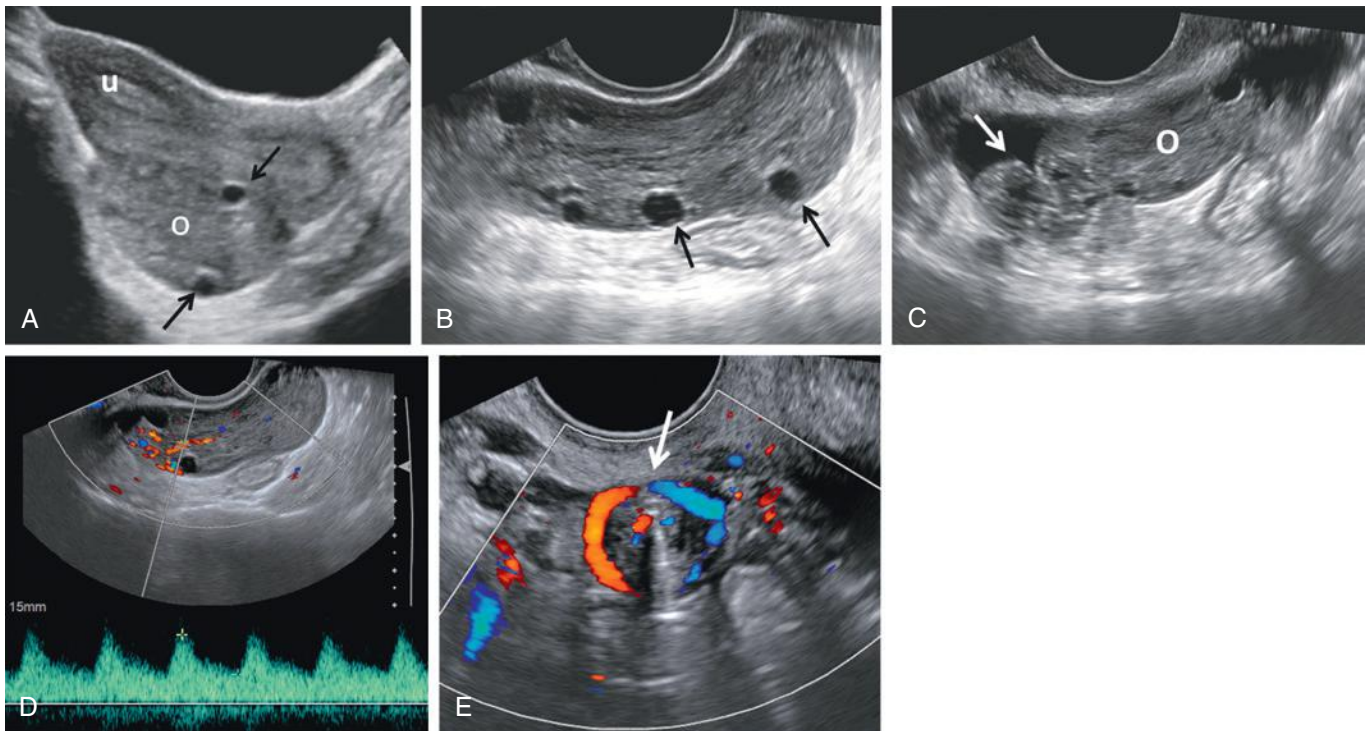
Ovarian torsion without associated mass and viable ovary. A, Transabdominal scan demonstrates the enlarged ovary (o) containing multiple peripherally arranged follicles (arrows). The ovary is located posterior to the uterus (u) midline in the cul-de-sac. B, At transvaginal evaluation, the ovary is enlarged and edematous with heterogeneous echotexture and peripherally located follicles (arrows), the “string of pearls” sign. C, Thickened congested vascular pedicle (arrow) is noted lateral to the ovary (o). There is a small amount of adjacent free fluid. D, Arterial flow to the ovary is preserved, shown with color and spectral duplex Doppler sonography. E, Whirlpool appearance of vascular pedicle (arrow) on color Doppler sonogram.
